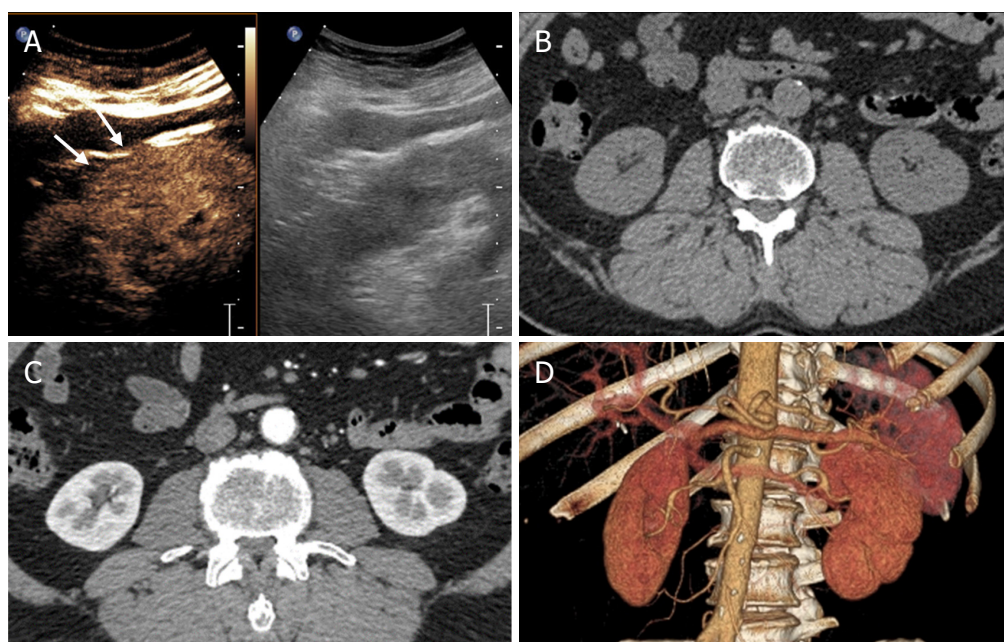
Pseudotumor. A: Grey-scale sonography shows isoechoic cortical mass (or dromedary hump?) in the midportion of the kidney (arrows); on contrast-enhanced sonograms the lesion shows enhancement equal (or similar) to the kidney in all vascular phases. Computed tomography with contrast injection before (B), after (C) and 3D reconstruction (D) doesn't show focal renal lesions
